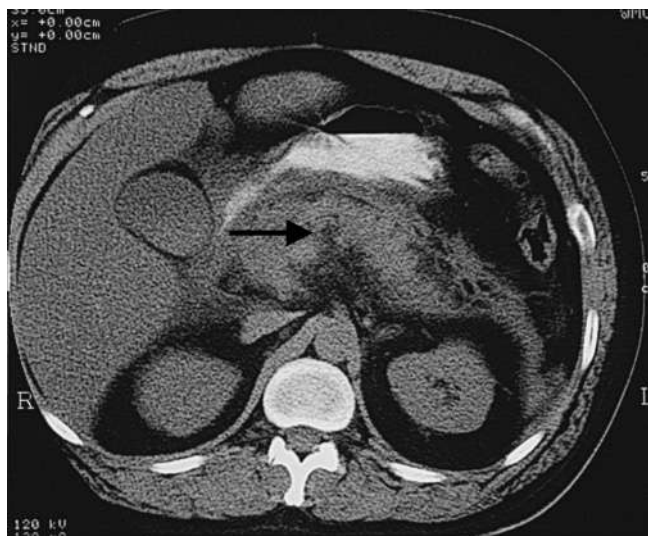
Acute pancreatitis. CT scan of the abdomen, showing marked oedema and swelling of the gland (arrow). Subsequently, a pancreatic pseudocyst developed.
